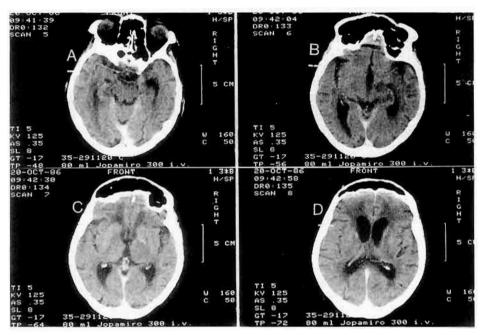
A-D: Cranial CT scans of the patient following radiotherapy show almost complete remission of the tumor. A small contrast-enhancing lesion is still apparent in the head of the left caudate (D). Note evidence of radiation-induced leukoencephalopathy with ventricular enlargement and periventricular lucency of white matter.
